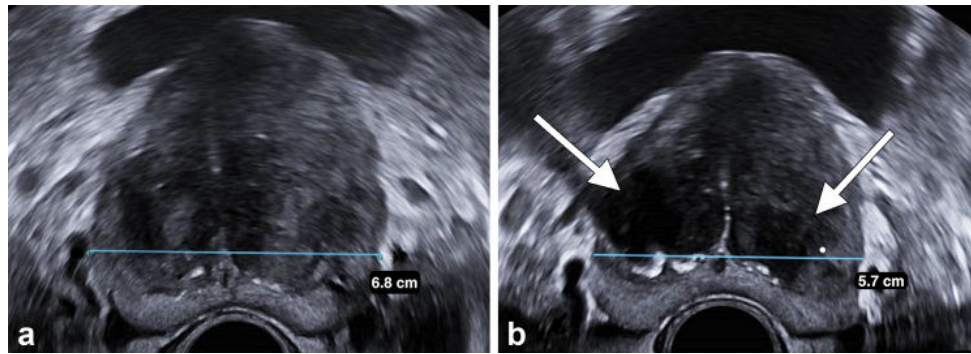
Ultrasound in B mode before (a) and after prostatic artery embolization (b), showing prostatic volumetric reduction (blue rule measuring maximum transverse diameter) and hypoechogenicity of the transitional zone (arrows).
